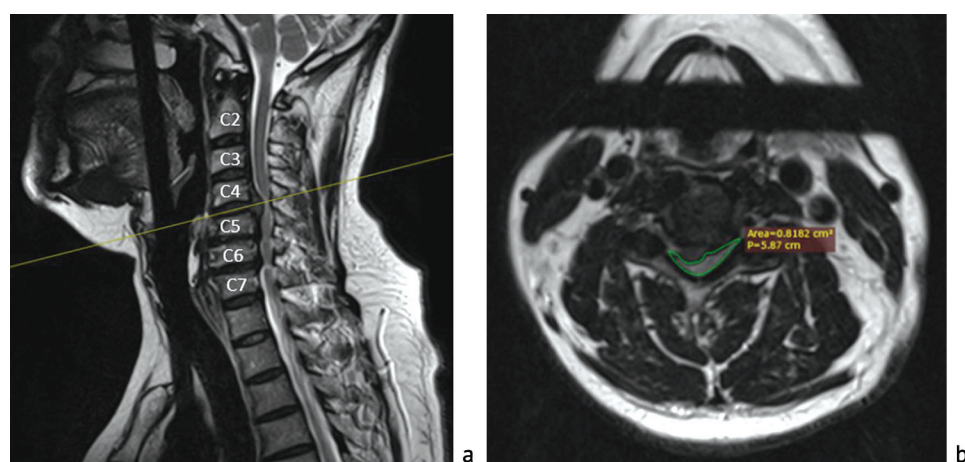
MRI of the cervical spine before surgery: a sagittal view; b axial view. Measurement of the cross-sectional area of the spinal canal with Radiant Dicom Viewer
